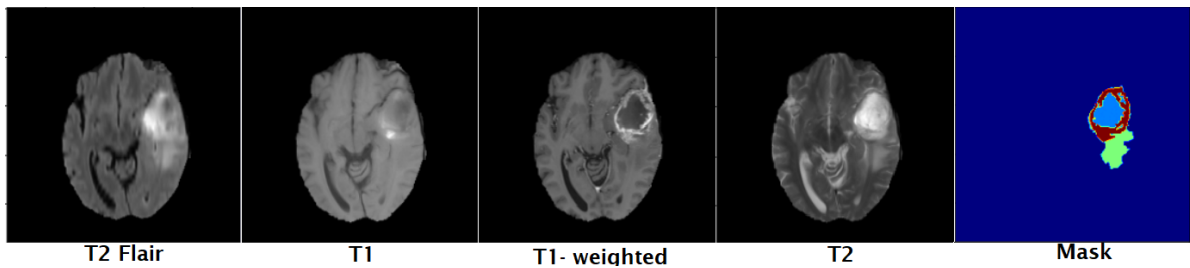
Slice of the MRI Image from Brats'19 dataset
